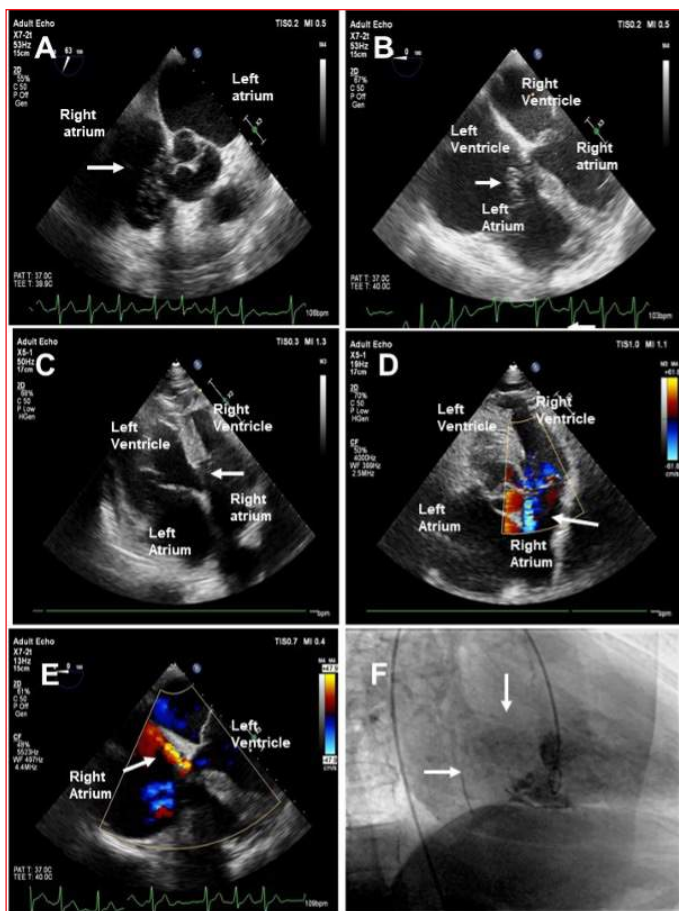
Gerbode type VSD. (A-B) Echocardiography view showed infective endocarditis-like images (C-D) Echocardiography revealed color doppler flow from the left ventricle to the right atrium (E) Ventriculography examination showed contrast view depicted flow for Gerbode type VSD left ventricle to the right atrium
